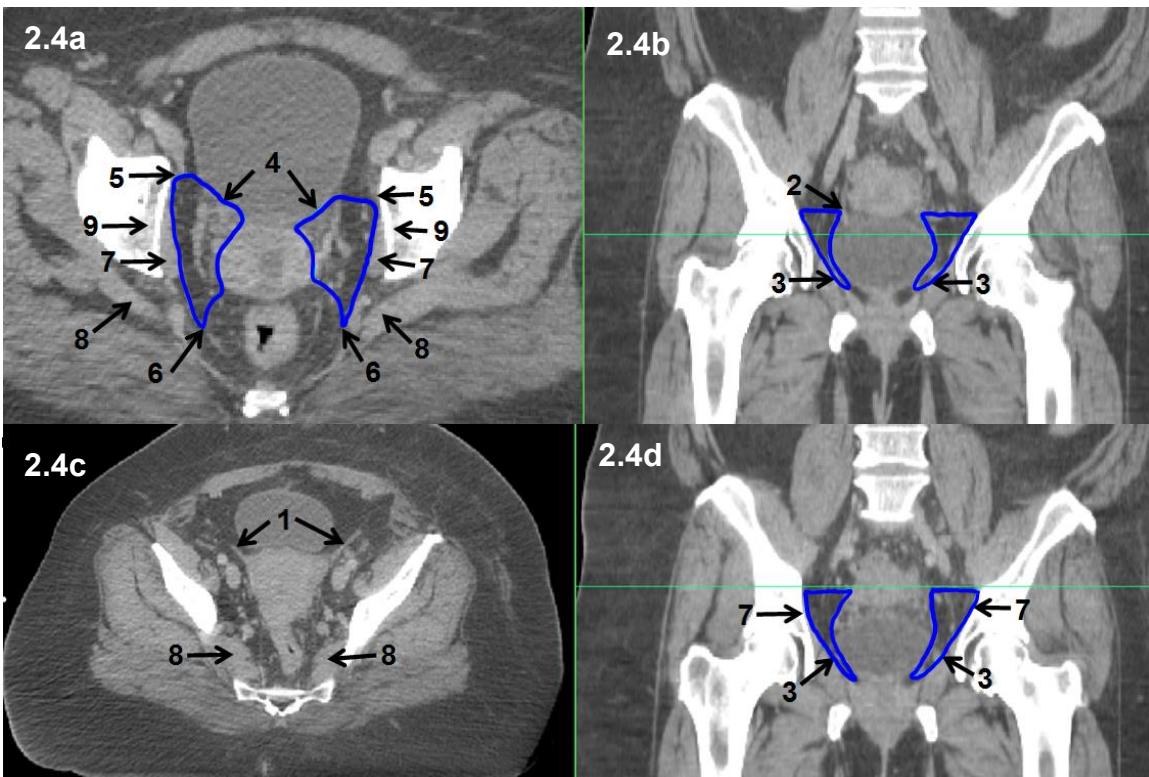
Axial (a and c) and coronal (b and d) CT with both parametria borders outlined; see table 1
